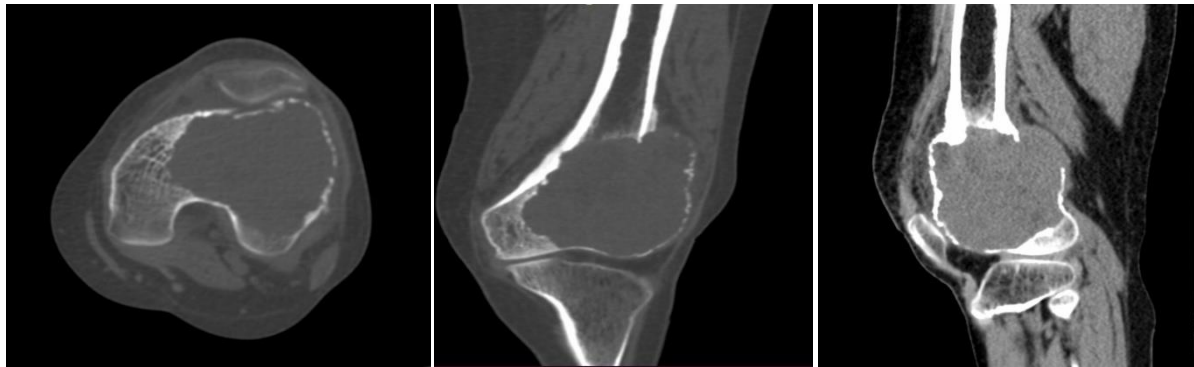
CT images –axial, coronal and sagittal cuts
